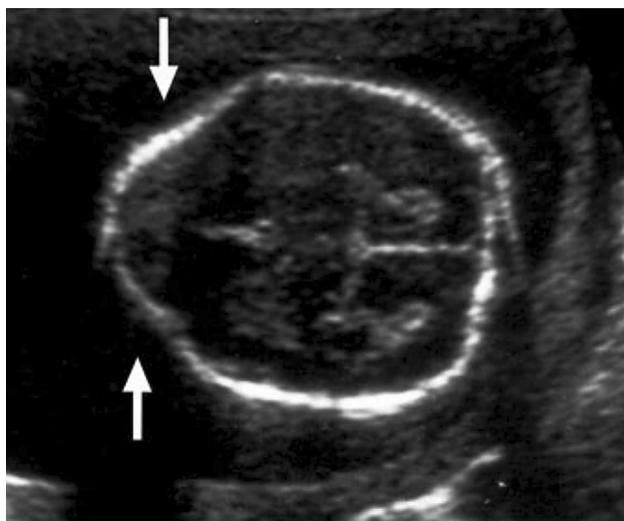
Typical prenatal sonogram of a lemon-shaped cranium, also referred to as the “lemon sign”, at the level of the ventricles. White arrows indicate the biconcavity of the frontal bones, resulting in a distinct lemon-like configuration [6]
